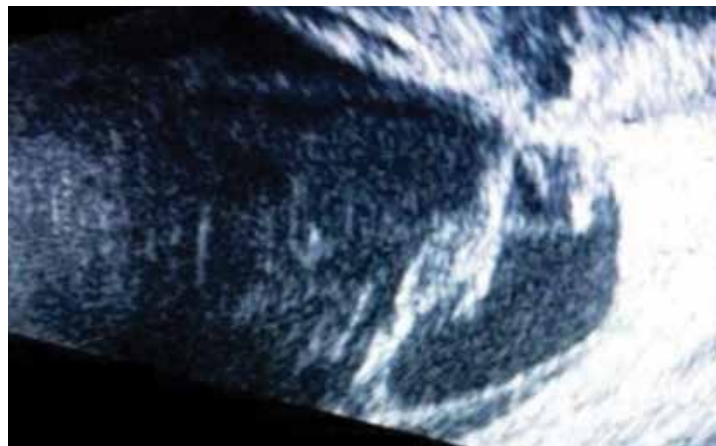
Preoperative ultrasound scan of the patient's right eye: retinal and choroidal detachment.
